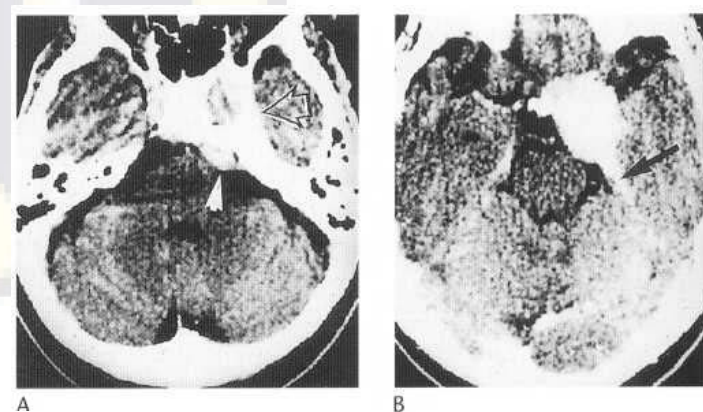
(A,B) Cavernous sinus petrous apex meningioma. CT after IV contrast medium. The left cavernous sinus is expanded (open arrow) in continuity with a mass at the petrous apex, which extends along the tentorium (arrow) and into the posterior fossa (arrowhead).
